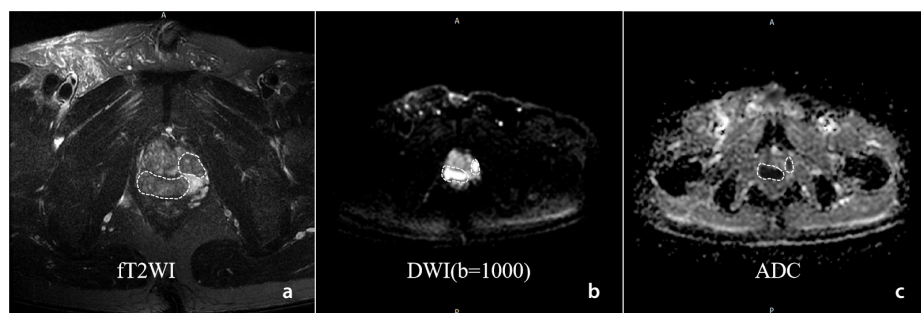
Tumor segmentation (dashed box) on different magnetic resonance imaging sequences, including T2WI (a), DWI ($b = 1000 \text{ s/mm}^2$) (b), and ADC map (c) (Software: Syngo Quick Brower). ft2WI, fat-suppressed T2 weighted imaging; DWI, diffusion-weighted imaging; ADC, apparent diffusion coefficient.
